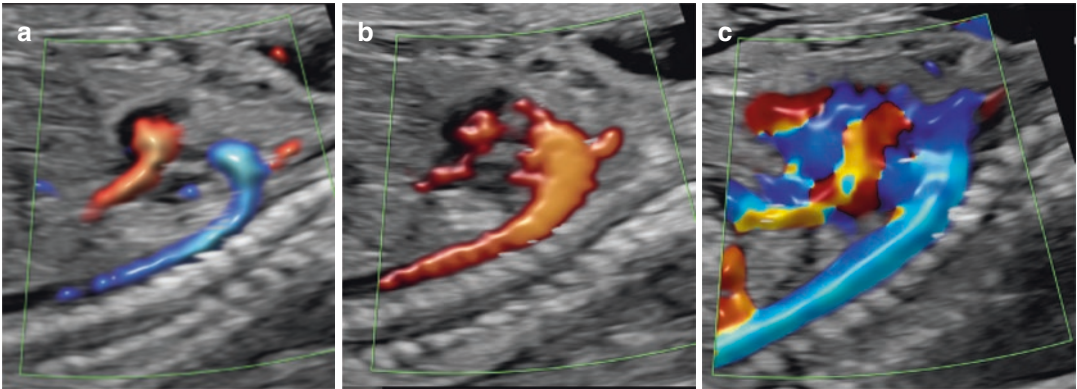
Comparison of color Doppler (A), power Doppler (B), and directional power Doppler (C) images of fetal aortic flow
